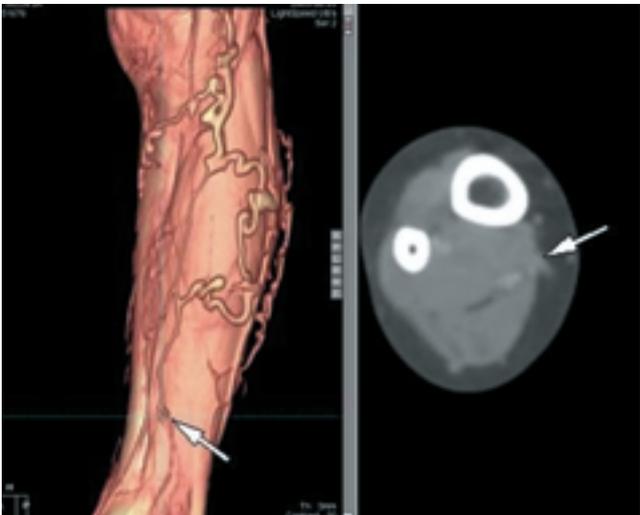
Volume rendering image of 3D-CTA shows the Cockett perforating vein (arrow) at the lower calf. Corresponding axial CT image shows the perforating vein connected to the deep venous system.
